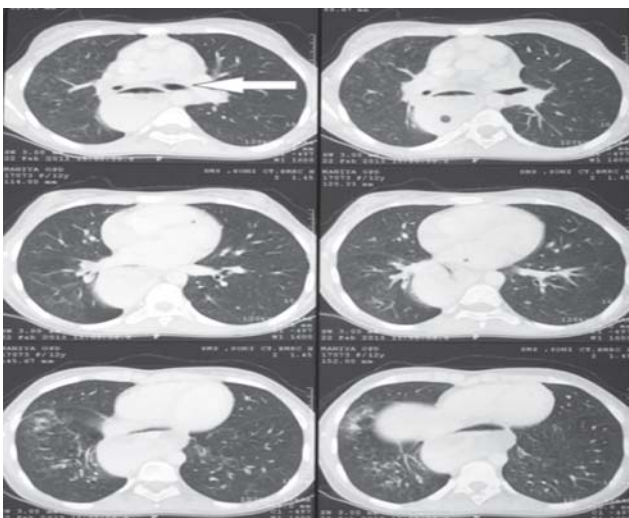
Computed tomography of the chest showing dilated oesophagus compressing surrounding airways (arrow).
